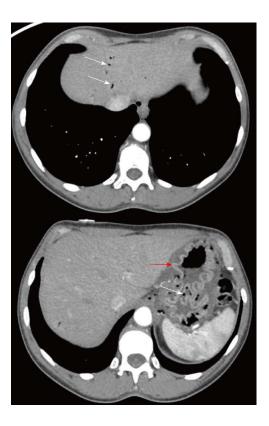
Computed tomography abdomen demonstrating portal venous gas as well as gastric pneumatosis and edema (portal venous gas and gastric pneumatosis noted with white arrows, gastric edema noted with red arrow).
